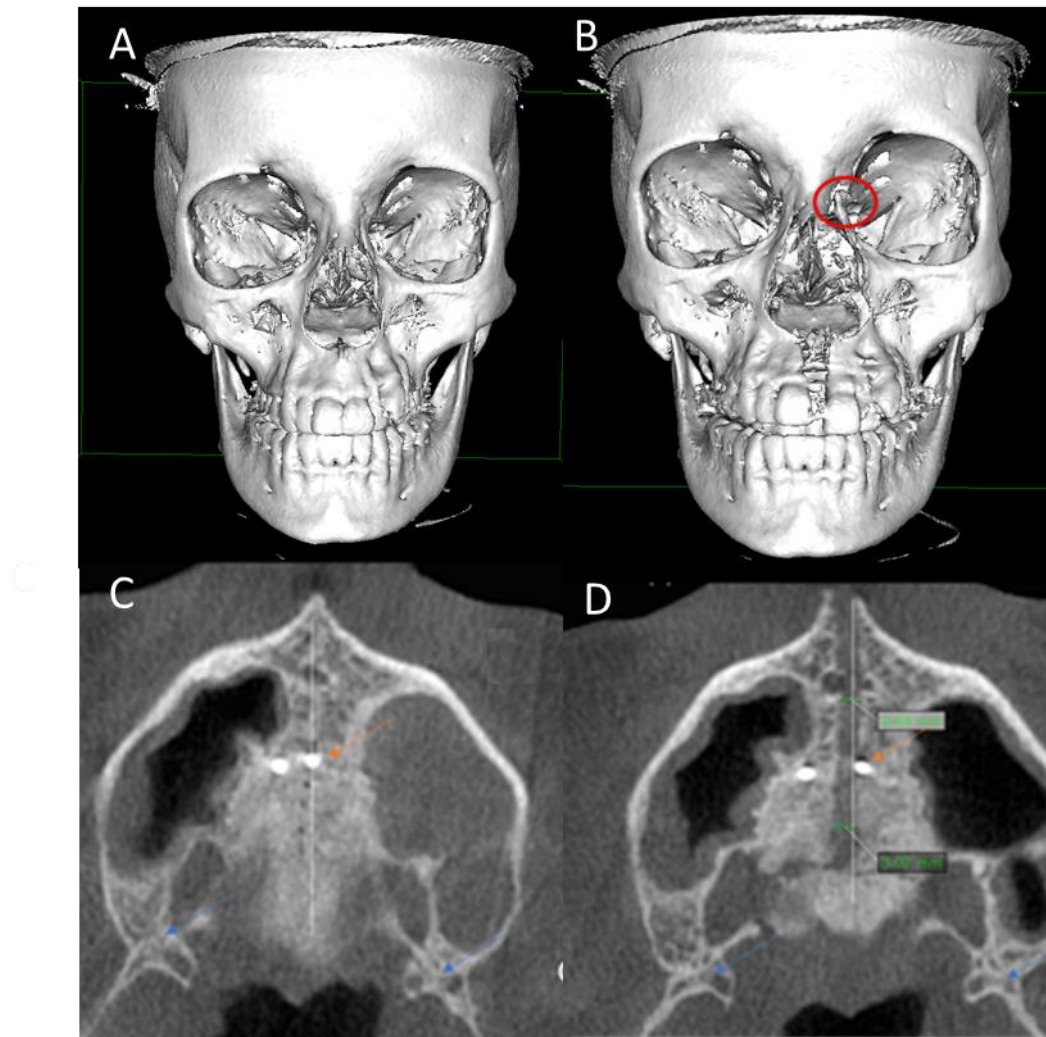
CT scans pre and post treatment with MARPE: A, initial 3D reconstruction. B, 3D reconstruction after MARPE expansion, frontonasal suture rupture is evident and is circled in red. C, axial section in the midpalatal suture region pre-expansion. D, Axial section in the midpalatal suture region after expansion.
